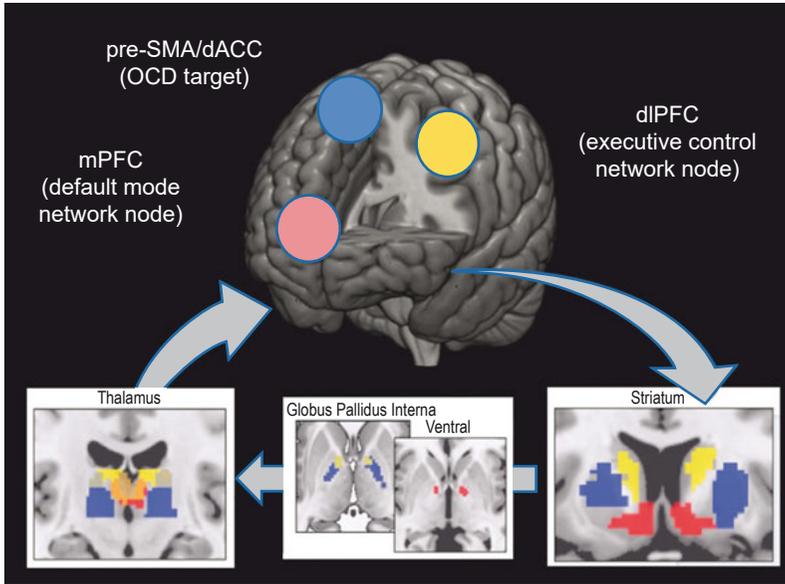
Candidate neural circuits amenable to modulation for intrusive thinking. Typically, therapeutic neuromodulation approaches require that a specific neural system be identified. The therapeutic strategy can then target the nodes of this neural system. This can be invasively (e.g., through deep brain stimulation) or noninvasively (e.g., using TMS, transcranial electrical stimulation, pulsed ultrasound). Three cortical nodes may be putative targets for neuromodulation based on their role in intrusive thinking and their striatal-thalamic connectivity: the medial prefrontal cortex (mPFC, red), the left and right dorsolateral prefrontal cortex (dlPFC, yellow), and the presupplementary motor area (pre-SMA, blue). The striatal, pallidal, and thalamic nodes of these circuits are shown in the lower panels. Adapted after Morris et al. (2016).
